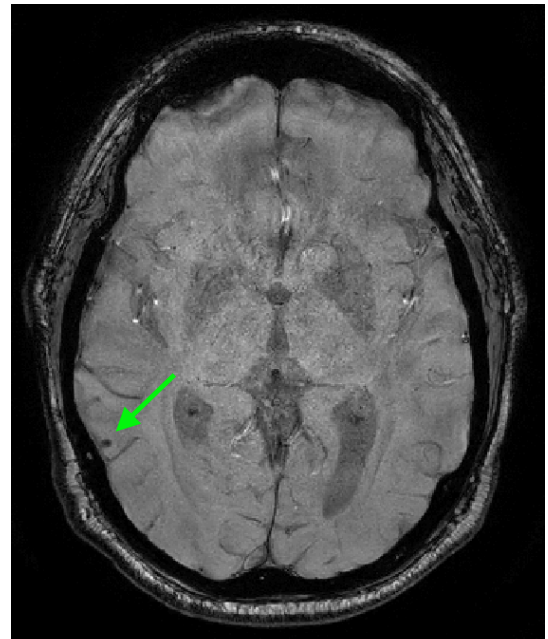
Microbleeds detected by MRI. The green arrow indicates a microbleed in a TBI subject.
